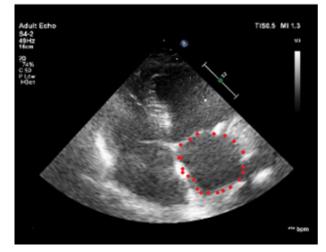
Bidimensional echocardiography. Apical view. Measurement of the left atrial surface.
